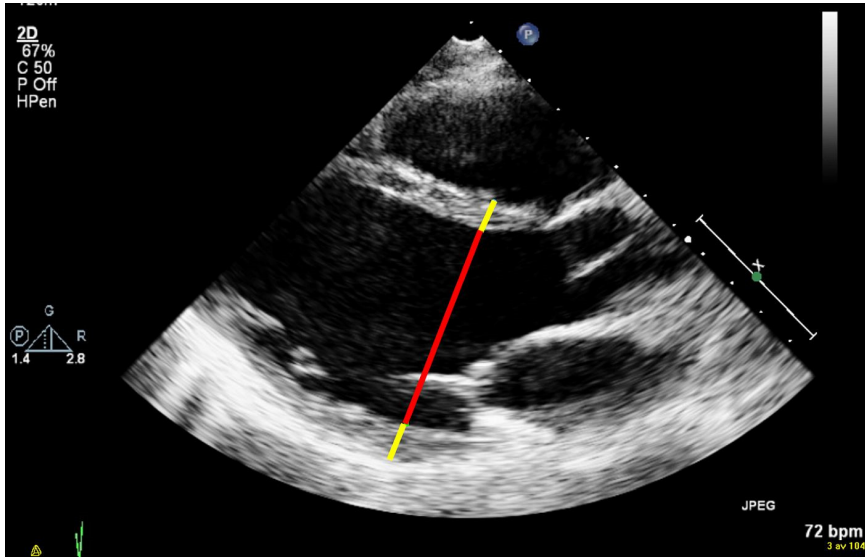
Parasternal long axis view with measurement of septal and posterior wall thickness (yellow lines) and diastolic inner diameter (red line).
